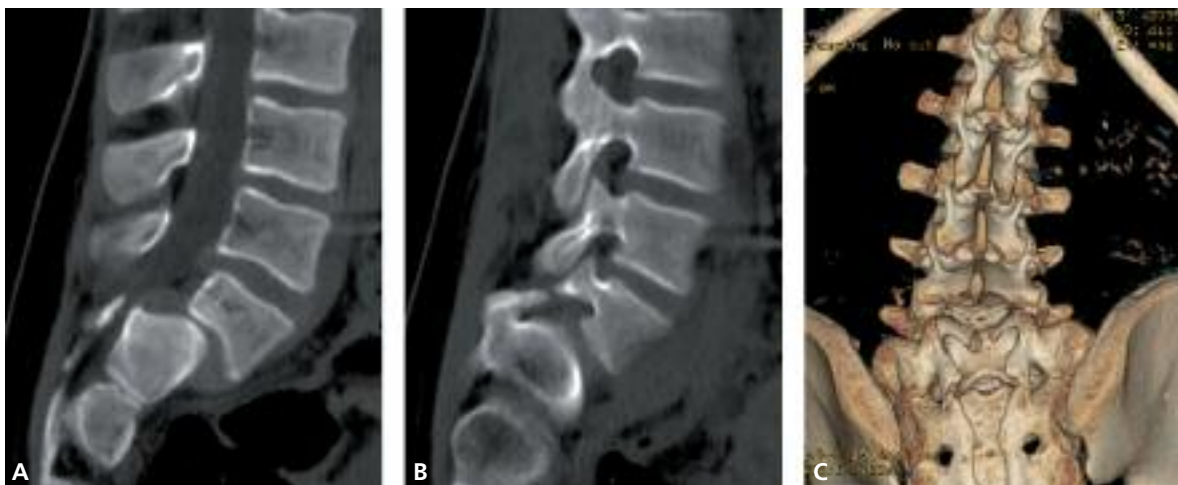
CT better highlighted the trapezoidal L5 body and its kyphotic tilt with respect to the sacrum, the significant bony defect in the posterior aspect, the presence of L5 spondylolysis.
